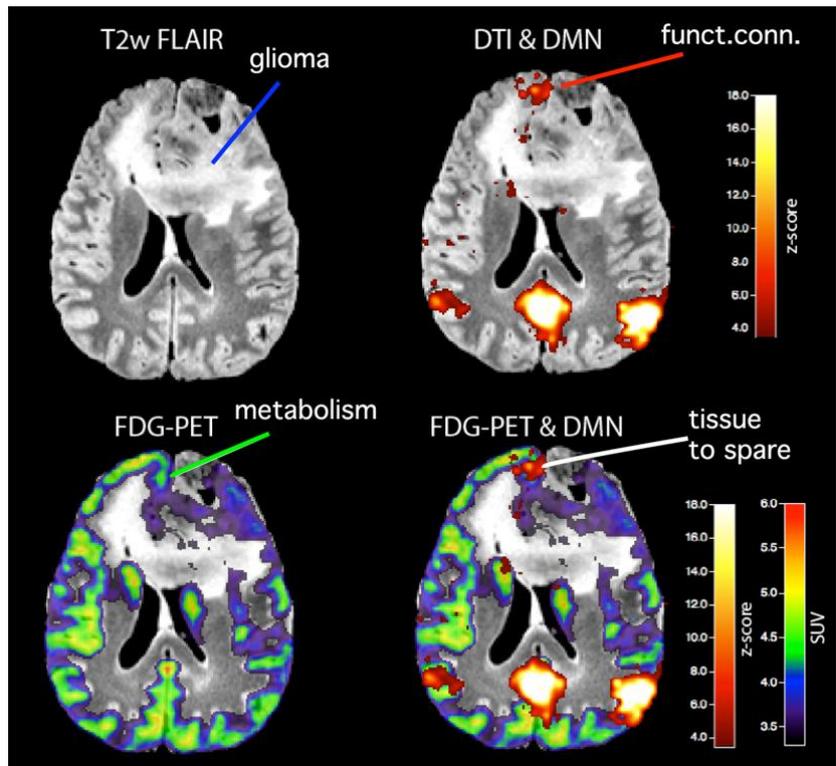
Multimodal imaging of brain tumors tags healthy tissue. Top (L) Anatomy (T2wFLAIR): glioma; (R): regions of connectivity (DTI&DMN), note healthy tissue (red line) near tumor; Bottom (L): Glucose metabolism (FDG-PET): connected tissue is metabolically normal (green line); (R) multi-modal fusion in neuro-navigator identify tissue to spare (white line).
